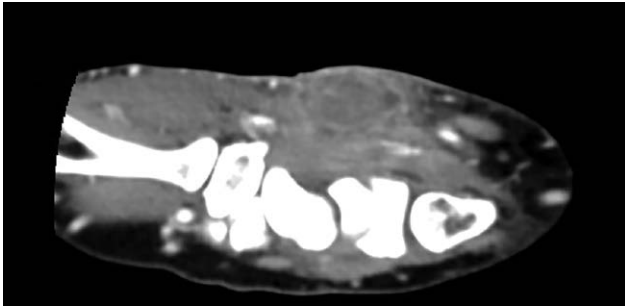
CT scan with contrast demonstrating a 1.0×2.0×7.1 cm fluid collection of the subcutaneous tissue superficial to the flexor tendons on the left wrist. There is slight widening of the scapholunate joint space.
